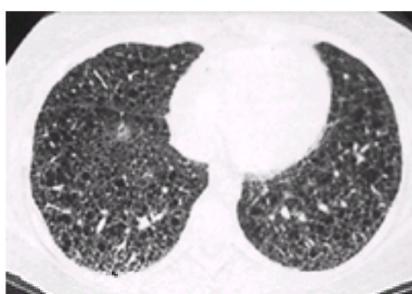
Tuberous sclerosis of lung evaluated by high-resolution computed tomography, showing typically diffuse fine honeycombing.
